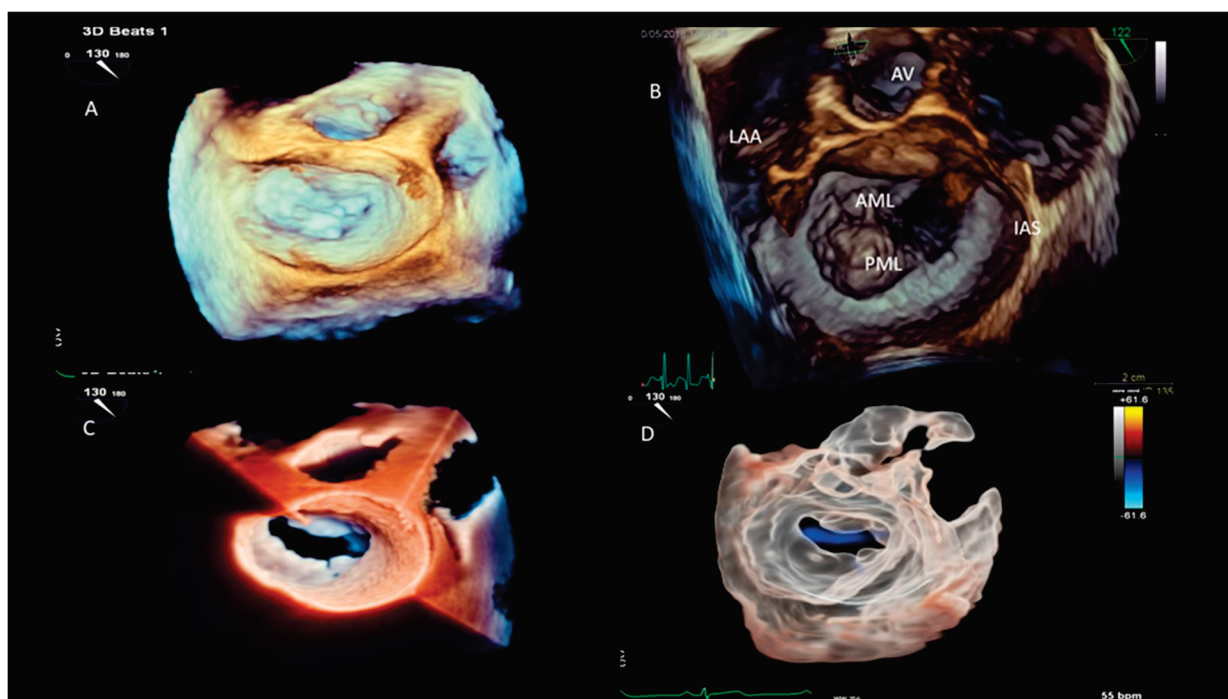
Three-dimensional image of mitral valve surgical atrial view. Panel (A) shows normal mitral valve with 3D echocardiography evaluation; panel (B) shows prolapse of mitral valve scallop P2; panel (C) shows normal mitral valve with TrueVue view modality; and panel (D) GlassVue view of normal mitral valve (LAA, left atrial appendage; AV, aortic valve; IAS, interatrial septum; AML, anterior mitral leaflet; and PML, posterior mitral leaflet).
